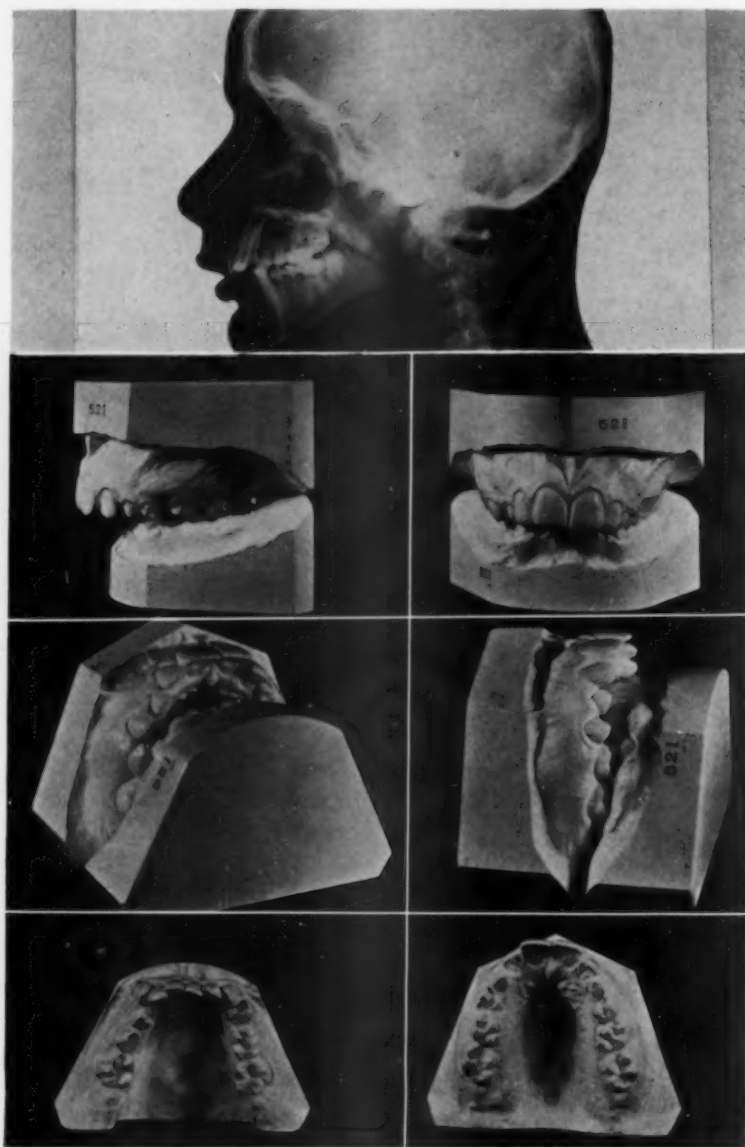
Headplate x-ray and models of a Type C case. Observe the lower anterior teeth and alveolar structure in relation to the chin point. In Types B and C cases observe the space between the posterior border of the ramus in relation to the vertebral column and compare this with the Type A cases.
